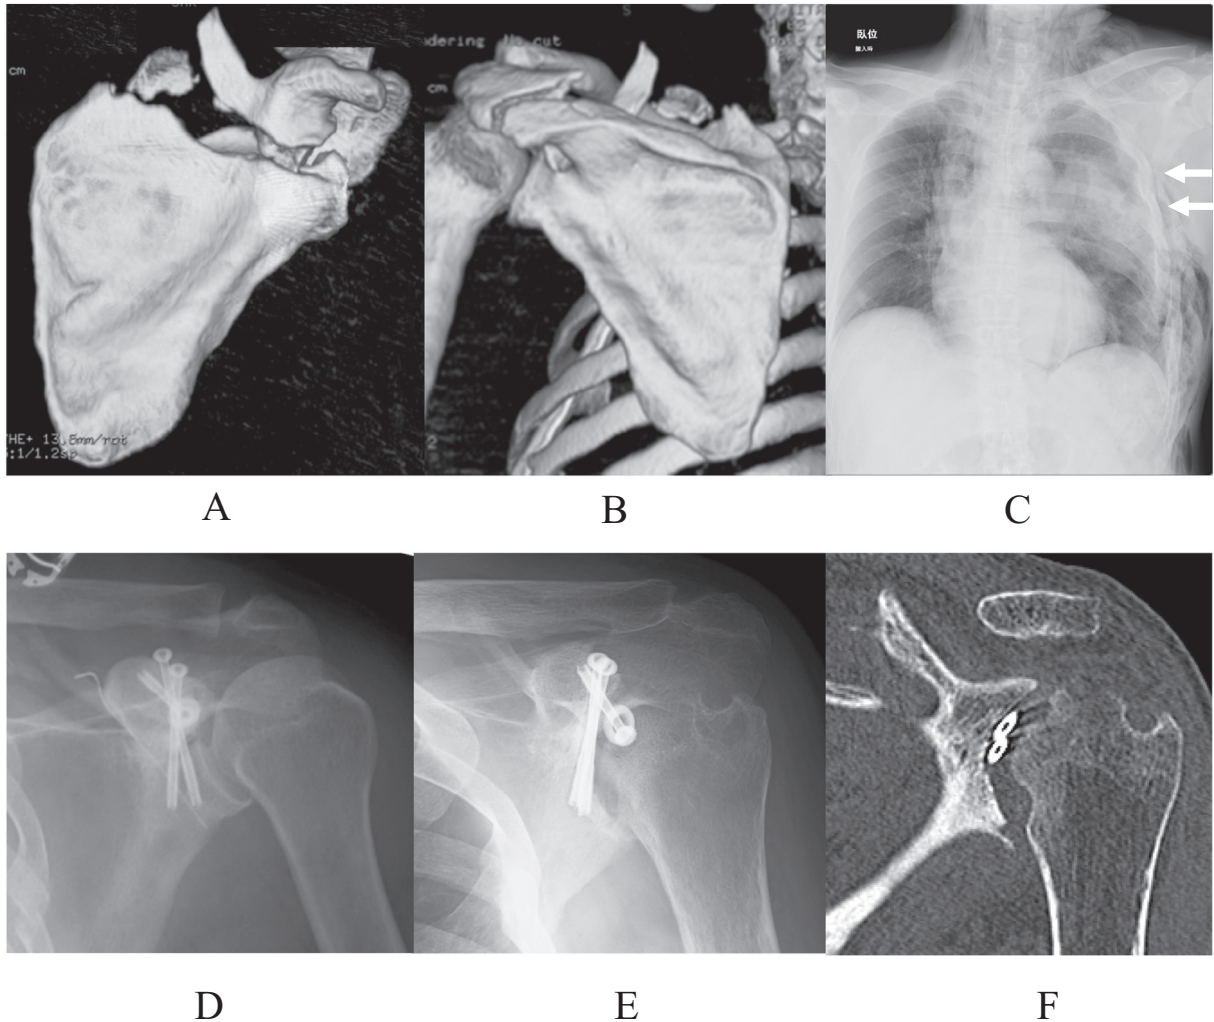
A 62-year-old male. A) Three-dimensional CT demonstrating right Ideberg type III glenoid fracture B) and acromion fracture. C) Anteroposterior radiograph demonstrating multiple right rib fractures. D) Postoperative anteroposterior radiograph. E) Anteroposterior radiograph 20 months after surgery demonstrating degenerative changes in the right shoulder joint. F) Coronal CT 20 months after surgery demonstrating that the two screws were in the shoulder joint.
